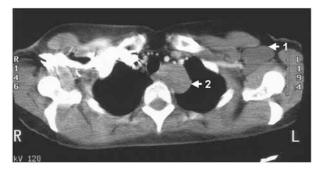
Axial CT scan of the neck showing: (a) left axillary tumour (plexiform neurofibroma); (b) tumour in the root of the neck (MPNST).
